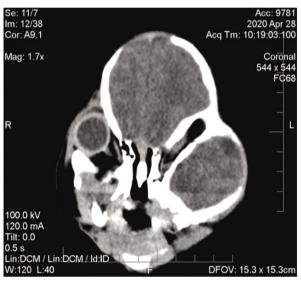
Head CT scan (coronal section)
